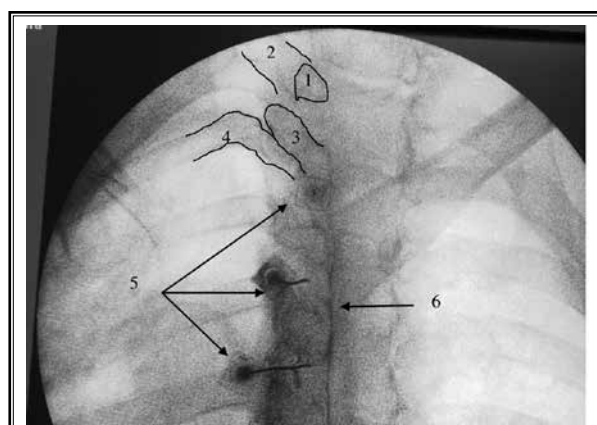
An oblique x-ray view of the upper thoracic spine depicting the DRG procedure. 1 = the pedicle of the first thoracic vertebra. 2 = the transverse process of the first thoracic spine (slanting upward and ballooned). 3 = the transverse process of the second thoracic spine. 4 = the second rib. 5 = the RF needles targeting the second, third, and fourth thoracic DRG (from above downward), the fluoroscopy is adjusted to see the RF needle targeting the second thoracic DRG (end on view). 6 = the arrow points to epidural spread of the dye.
